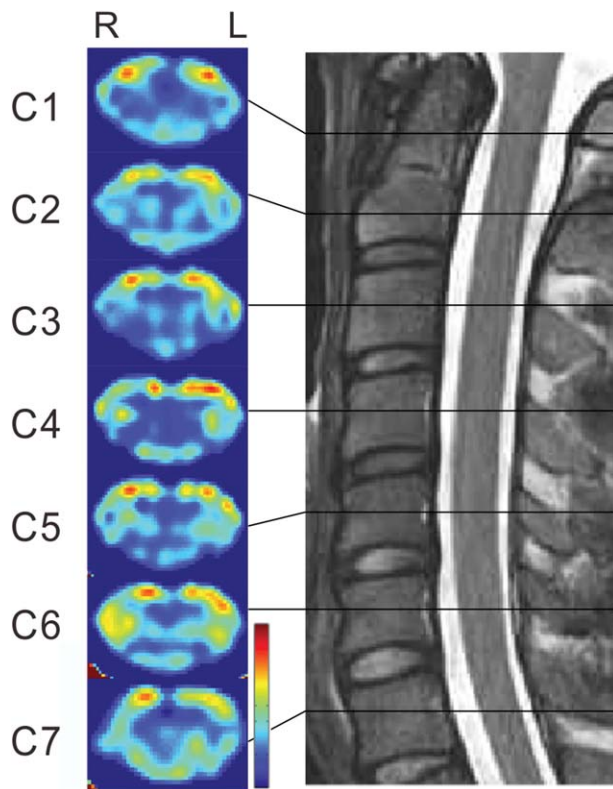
T1w/T2w ratio images at each cervical vertebral level. The right side of the figure shows the sagittal cervical T2w MR images. Axial T1w/T2w ratio images at each vertebral level (C1–C7) are shown on the left side of the figure (ventral at the top). High contrast between the GM and WM is seen at all cervical segments, but the so-called “butterfly” shape is the clearest at C4. The scale is 10–90% for each image.
